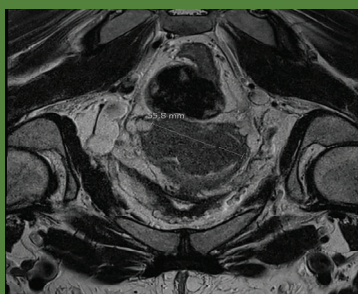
Cervical mass (coronal view, MRI)
